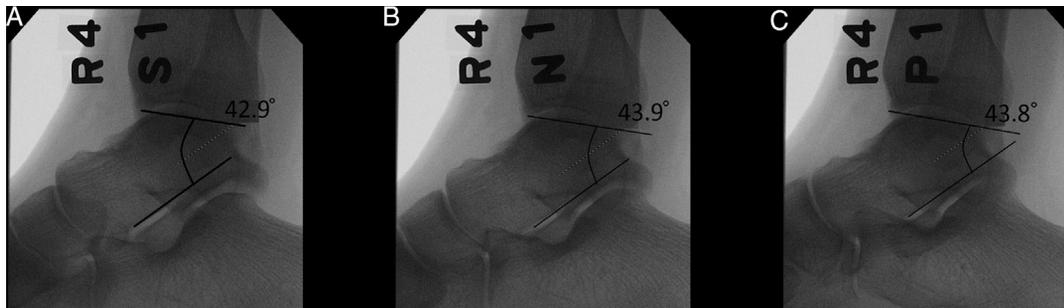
Radiographs from 1 subject with the foot in (A) supination, (B) neutral, and (C) pronation showing very little actual change in the radiographic tibiotalar position. One line was drawn posterior to the anterior lip of the distal tibial plafond. The second line was drawn along the inferior aspect of the talus at the parallel to the surface of the posterior subtalar joint facet.
